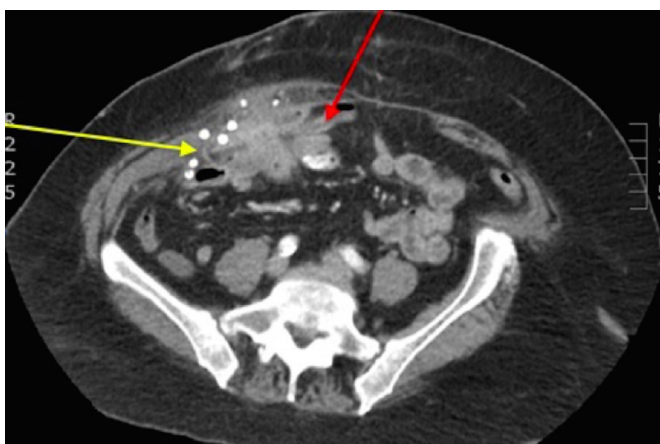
Transverse CT image showing the inflammatory mass in the right iliac fossa. The non-absorbable titanium tacks are clearly seen. This inflammatory mass incorporates the synthetic mesh (which has migrated laterally, shrunk and become coiled, yellow arrow) and loops of bowel (red arrow).
